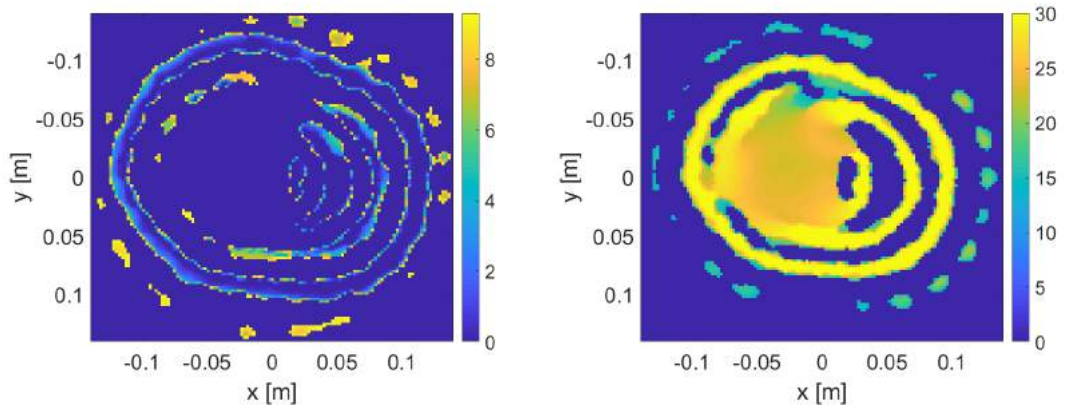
K-means clusters from the imaginary part relative permittivity images in MRI models 1, 2, and 3 using Glycerin/Water solution (Left = *Low-Permittivity*, Right = *High-Permittivity*).
